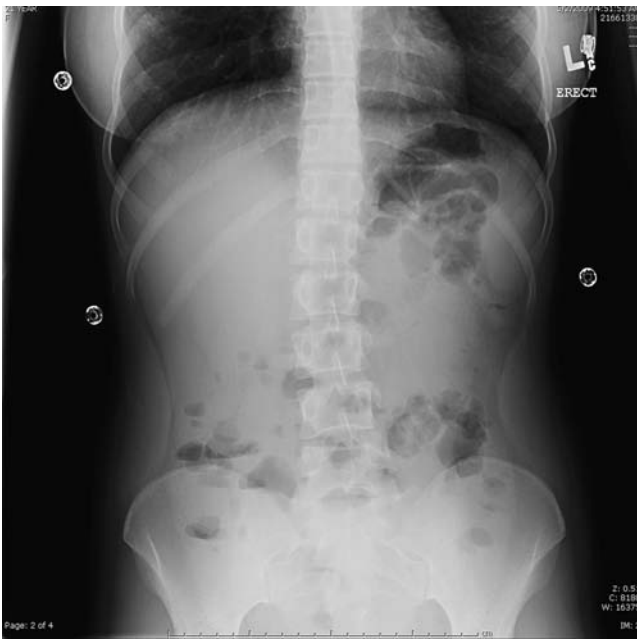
Radiograph showing distal intestinal obstructive syndrome.
